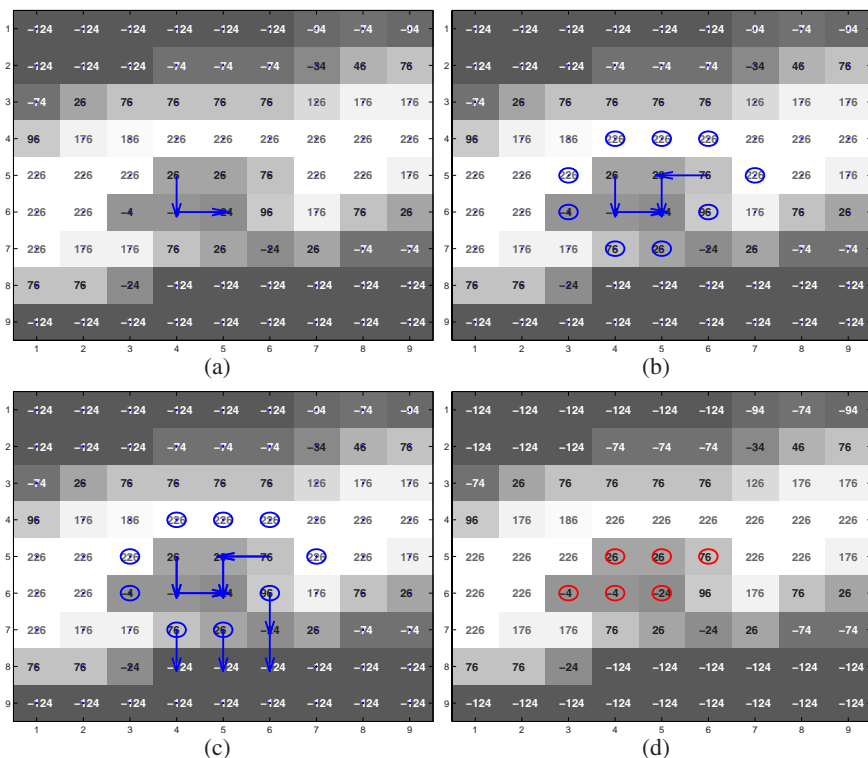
Using the concentration oriented toboggan algorithm for PE detection. (a) Step A of the algorithm: Finding the concentration. (b) Step B: Expanding from the concentration to cover a whole toboggan cluster and providing all the external boundary pixels (circled). (c) Repeatedly apply the algorithm on all those external boundary pixels with CT value between -50 HU and 100 HU to form a PE candidate, leading to an identical result (d) as in Fig. 2.(b).
